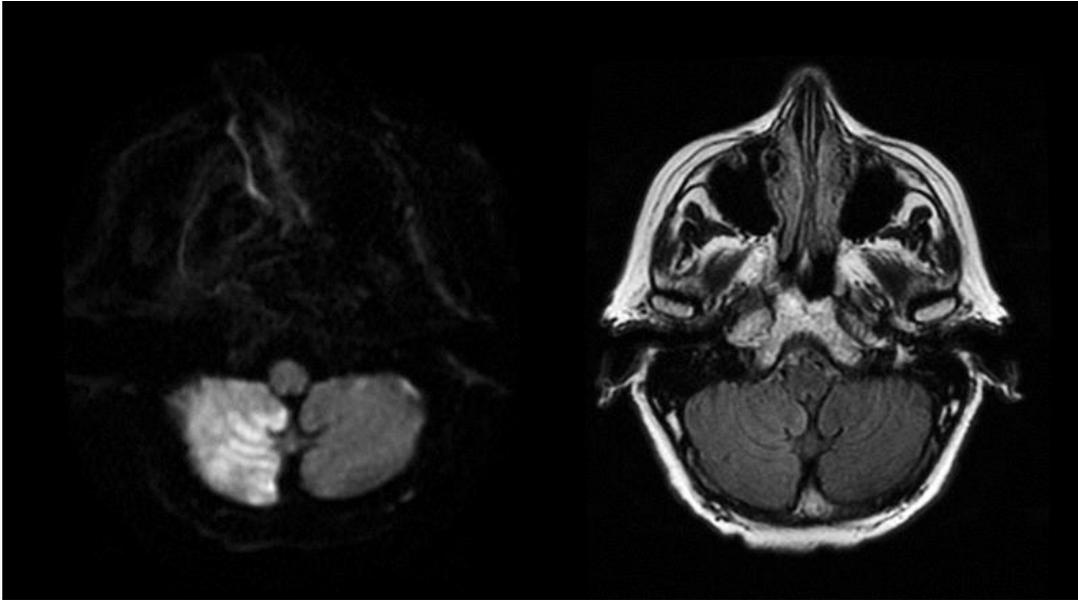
Complete DWI-FLAIR mismatch of a right cerebellar infarct.
